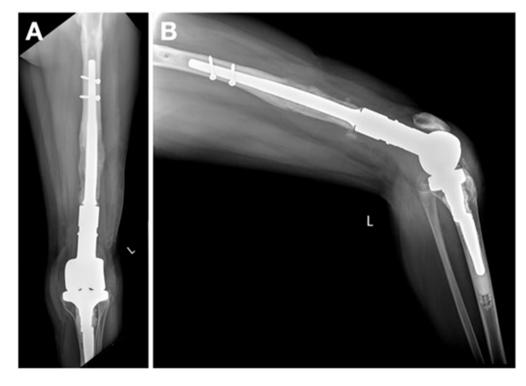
Anteroposterior (A) and lateral (B) x-ray images demonstrating the implanted definitive modular MUTARS® endoprosthesis
